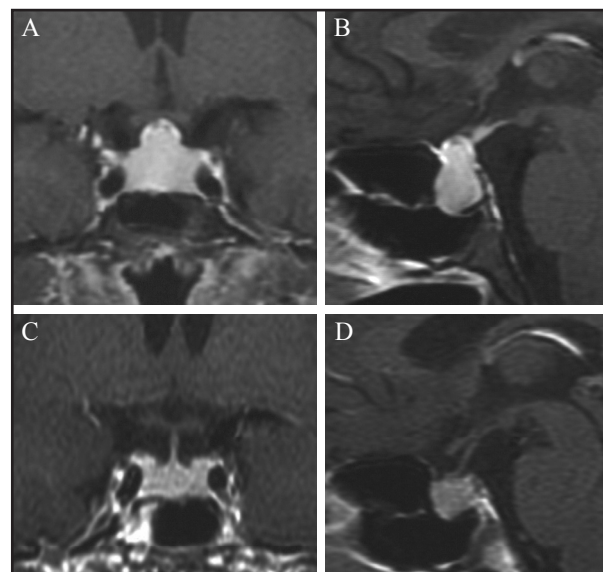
Initial coronal (A) and sagittal (B) gadolinium (Gd)-enhanced T1-weighted magnetic resonance imaging (MRI) scans show a homogeneously enhancing intrasellar mass with suprasellar extension. After 5 months of thyroid hormone replacement, coronal (C) and sagittal (D) Gd-enhanced T1-weighted MRI scans reveal decrease in size of the pituitary mass.
